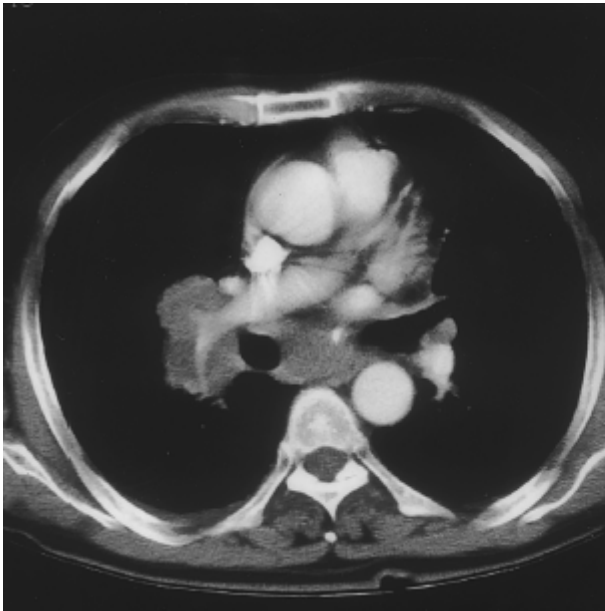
Initial computed tomography of the chest showed multiple, diffuse para-aortic lymphadenopathy and lung mass at right hilum.
